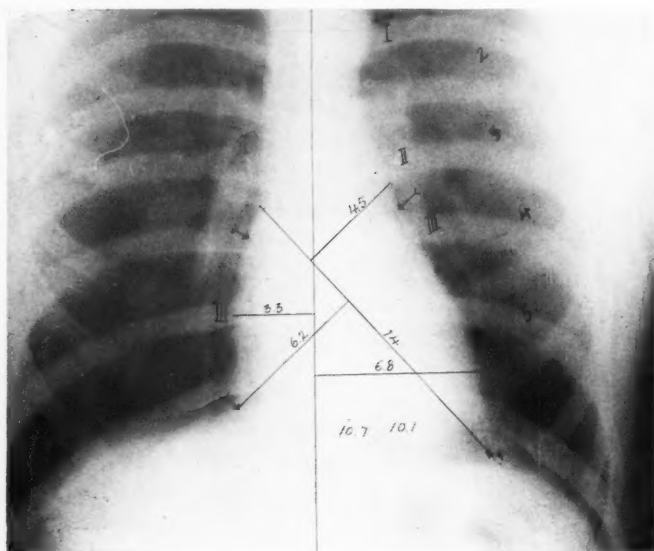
Radiograph of a normal heart taken at the tube film distance of 6 feet. The curves of the various portions of the heart and great vessels are indicated according to Fig. 194.
